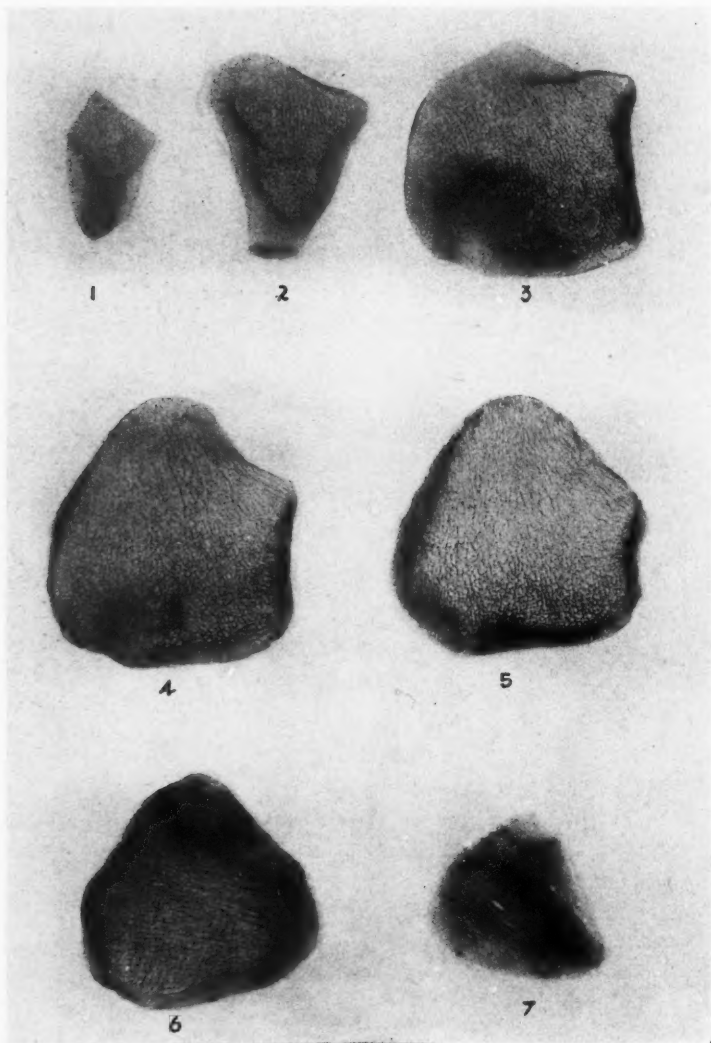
Figs. 1 to 7. Roentgenograms of a single human patella, cut in serial coronal sections, section 1 mm. thick. Figure 1 is the dorsal or articular member of the series and Figure 7, the ventral member of the series. Figure 7 is composed primarily of the compact longitudinal traction trabeculae. Figure 4, through the center of the patella, is composed of pressure pillars cut in cross-section (natural size).
